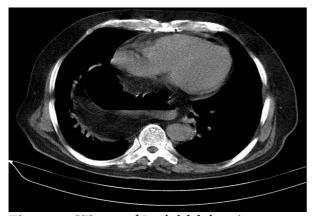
CT scan of Bochdalek hernia
